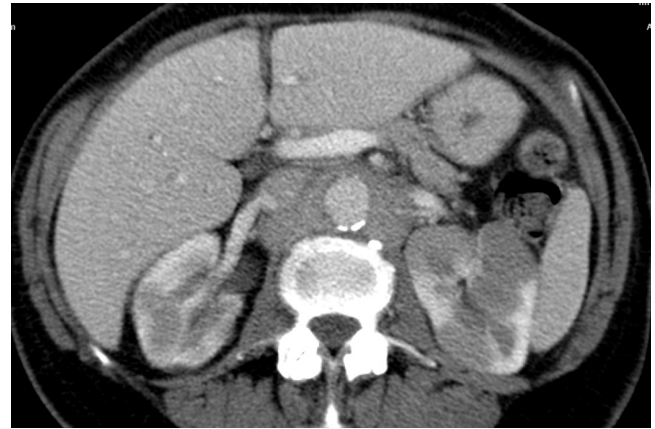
■ Lymphoma of the kidney. Post-contrast CT demonstrates multifocal solid masses in both kidneys with para-aortic nodal disease highly suggestive of lymphoma. Biopsy of the renal mass is required to confirm and characterise before treatment, which will not be surgical.
